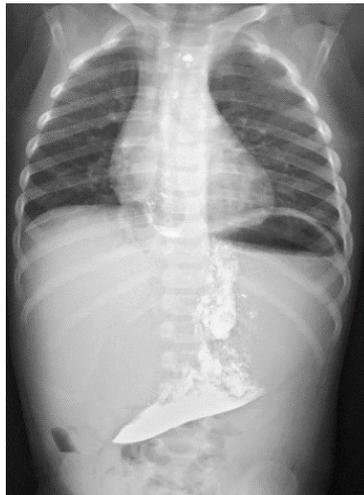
Patient I.M. Chest and abdominal X-ray on the 7th day postoperatively (the explanation is in the text).
